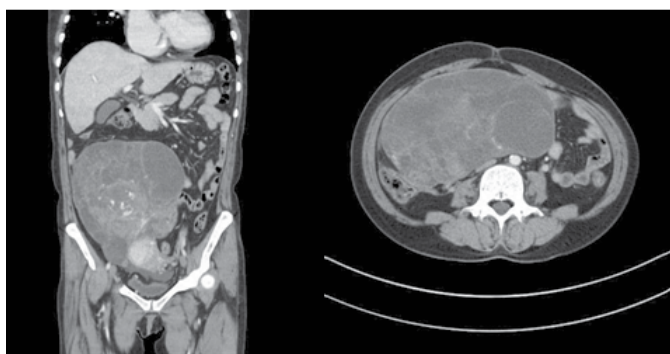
Computed tomography scan showed a large multiseptated cystic mass (20 cm) with soft tissue parts, multiple hemorrhage and fluid-fluid levels and uterus was normal.
